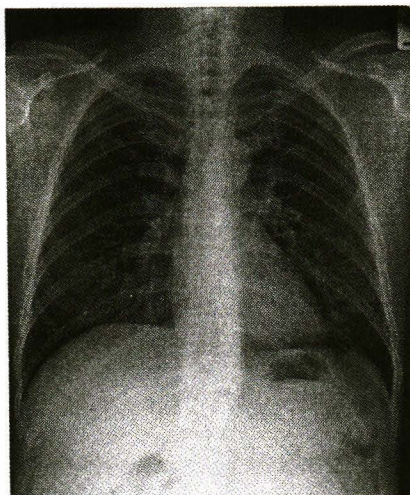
Within 48 hours after the therapy, a follow-up chest radiograph demonstrates a complete resolution of the infiltrates.
